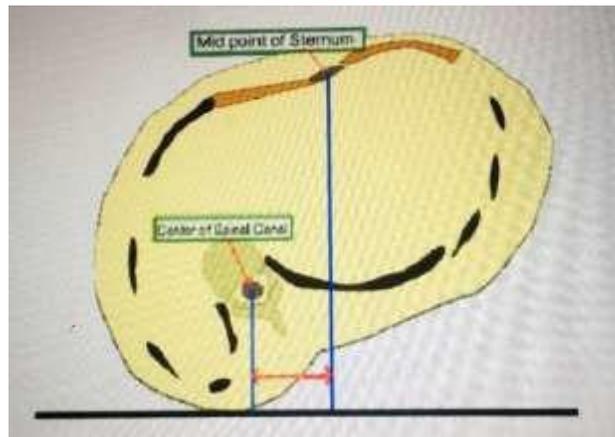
Measurement of the vertebra translation (VT) in axial section of the CT scan. Measured in millimeters as the horizontal distance between the line dropped from the center of the spinal canal and the center of the sternal width, [modified from Easwar et al 2011 [140]].
